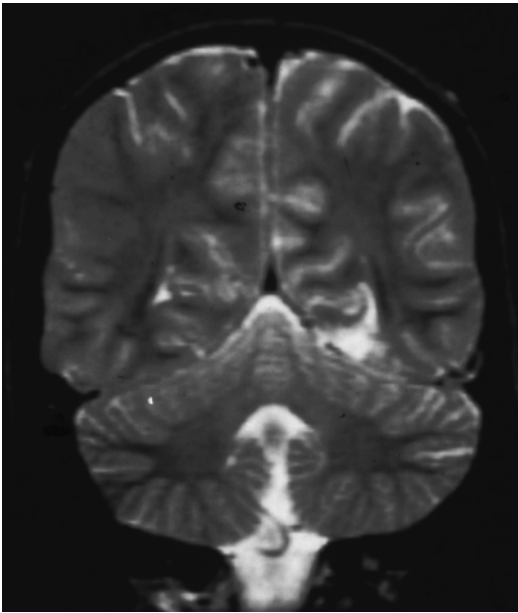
Focal left occipital-temporal cortical maldevelopment; visual prodrome reported by epilepsy patient in advance of generalized seizure activity corresponding to focal left inferior occipital-temporal cortical lesion seen on coronal T2 MRI
